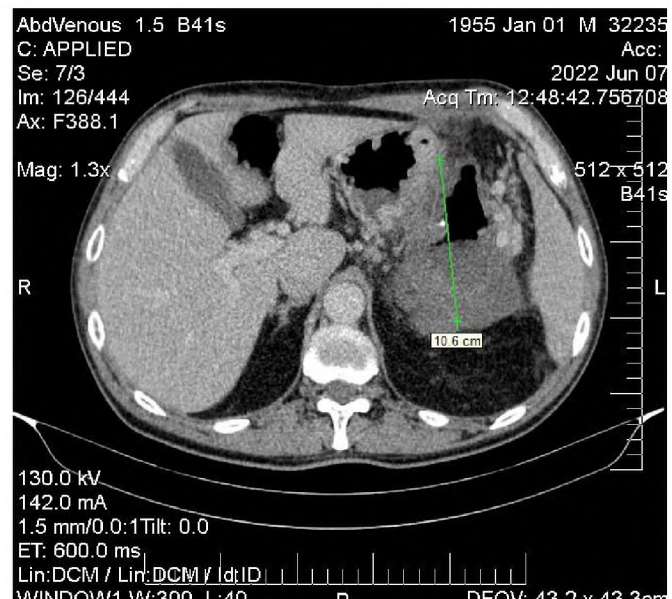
CT data 07.06.2022, tumor 104x93x84 mm
